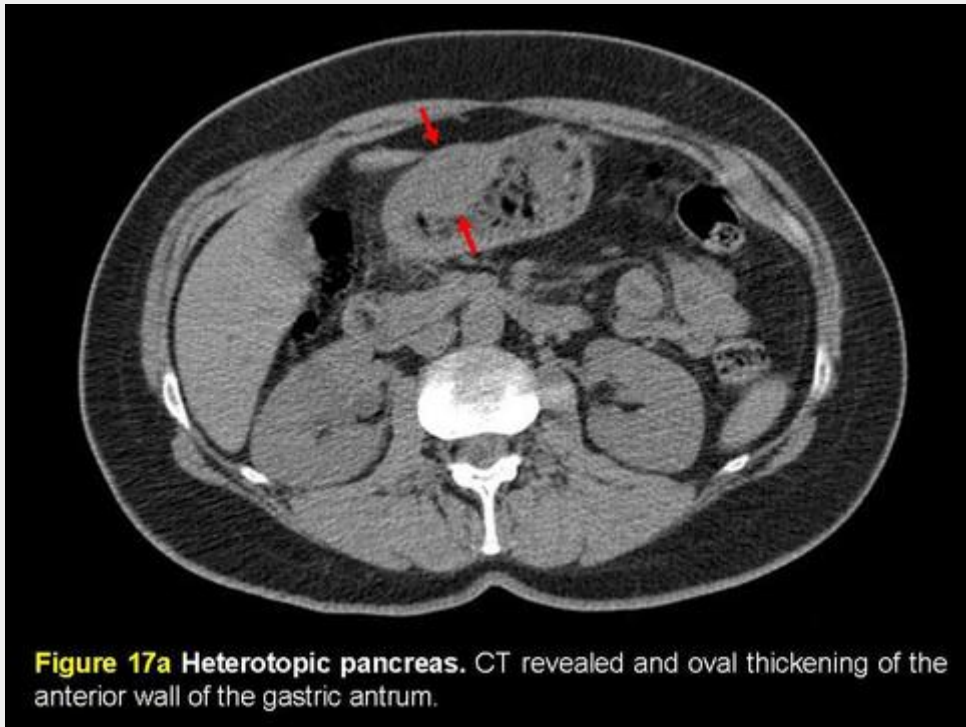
Heterotopic pancreas. CT revealed and oval thickening of the anterior wall of the gastric antrum.
